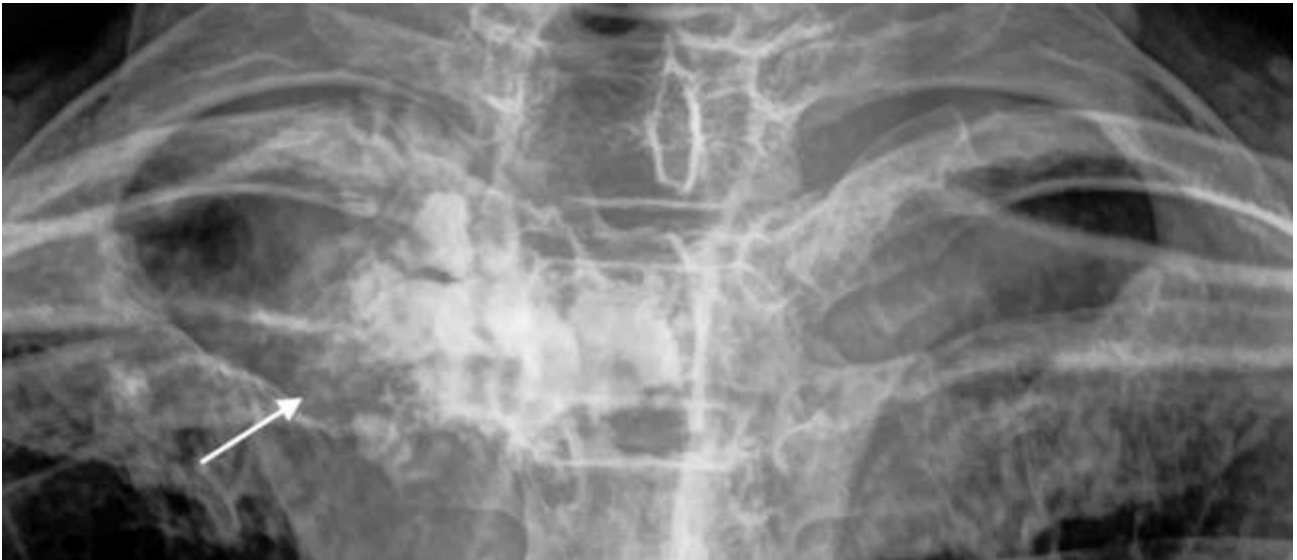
Plain radiograph of the thoracic region demonstrating unilateral flowing cortical hyperostosis involving the right posterolateral aspect of the upper thoracic vertebra and adjacent rib (arrow), producing the characteristic "dripping candle-wax" appearance. No cortical destruction, bone expansion, or aggressive periosteal reaction is identified.
